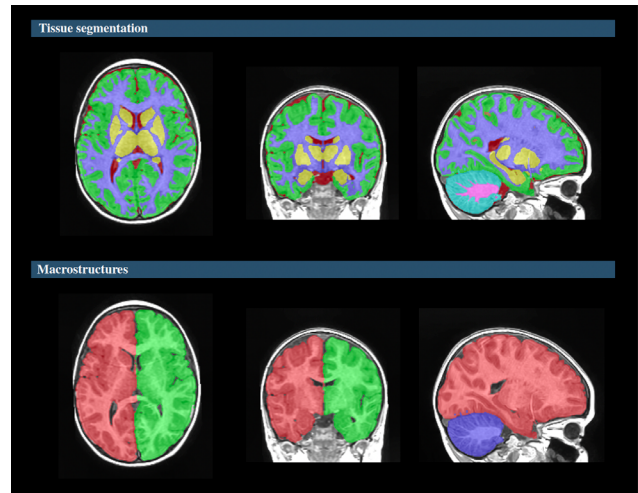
Brain MRI volumetric analysis of cases with the Volbrain program
